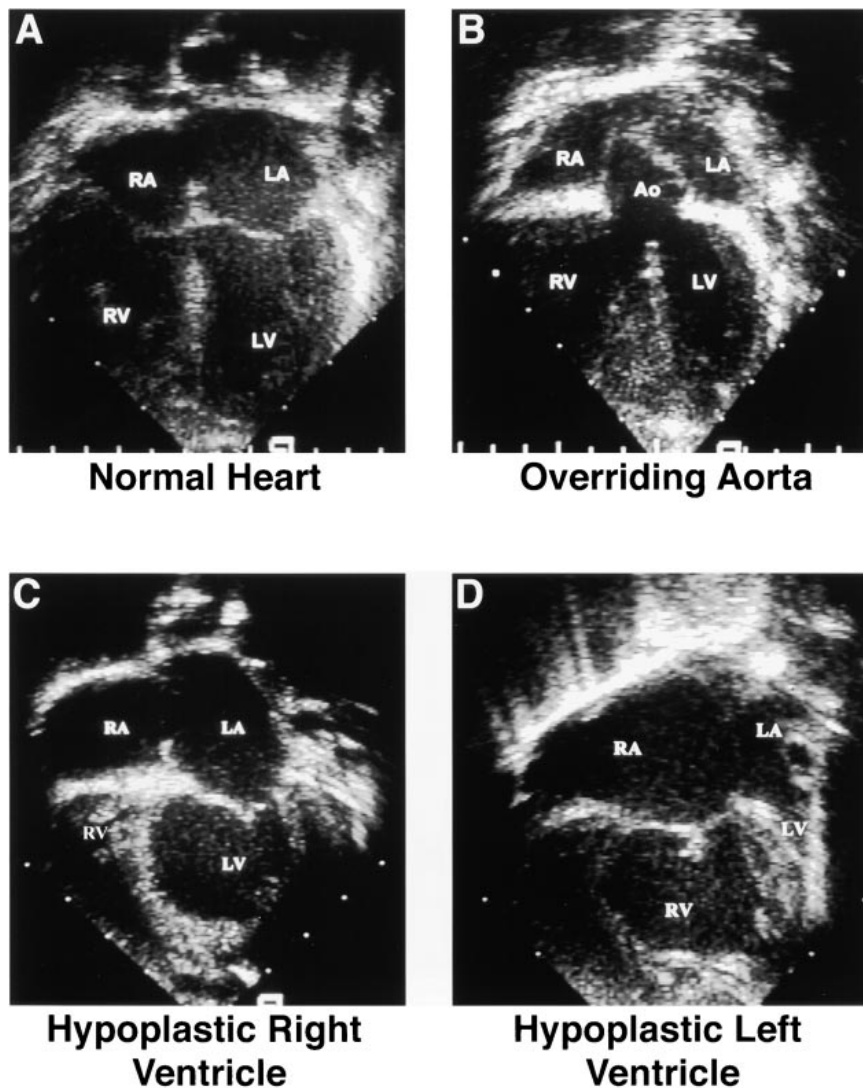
Segment-specific cardiac defects in human hearts. Two-dimensional ultrasound images of a normal heart (A) with four chambers including the right atrium (RA), left atrium (LA), right ventricle (RV), and left ventricle (LV). Malalignment of the aorta, seen in a variety of neural crest-related defects results in the aorta (Ao) overriding the ventricular septum (B) instead of connecting with the LV. Hypoplasia of the right (C) or left (D) ventricle can occur with the remaining ventricle being morphologically and functionally normal.
